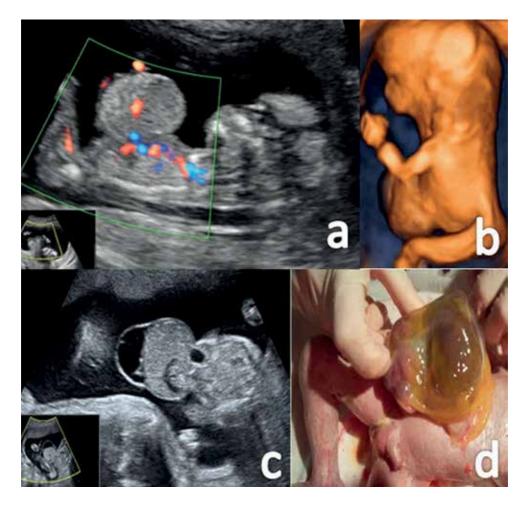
a. Ultrasound image of omphalocele diagnosed in the first trimester (a. Color Doppler image, b. 3D image); c. US image of omphalocele diagnosed in the second trimester; d. Postnatally image of omphalocele.
